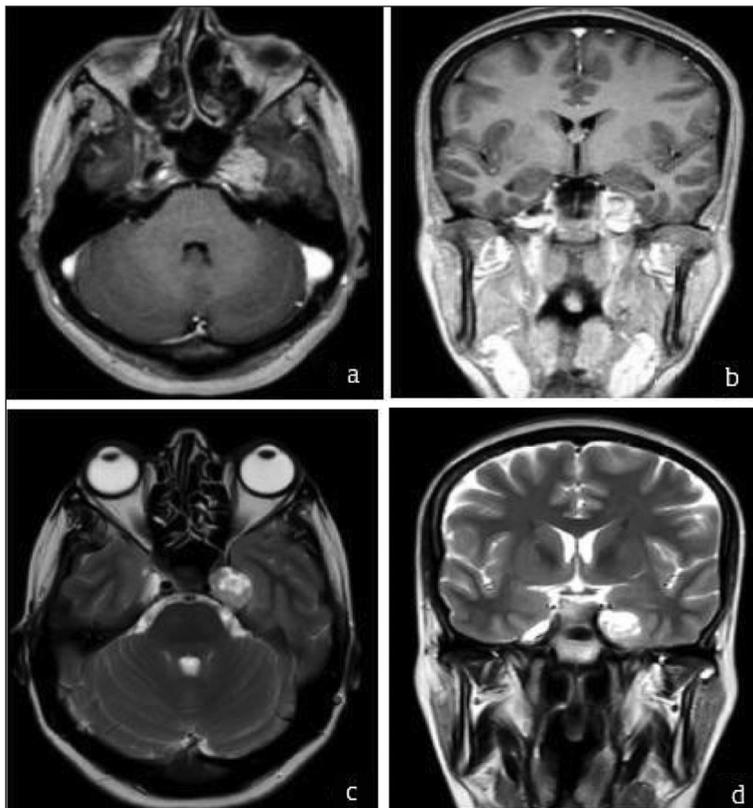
Contrast-enhanced T1 cranial magnetic resonance imaging axial (a) coronal (b), T2 axial (c) and coronal (d) image sections show a trigeminal schwannoma adjacent to the cavernous sinus.
